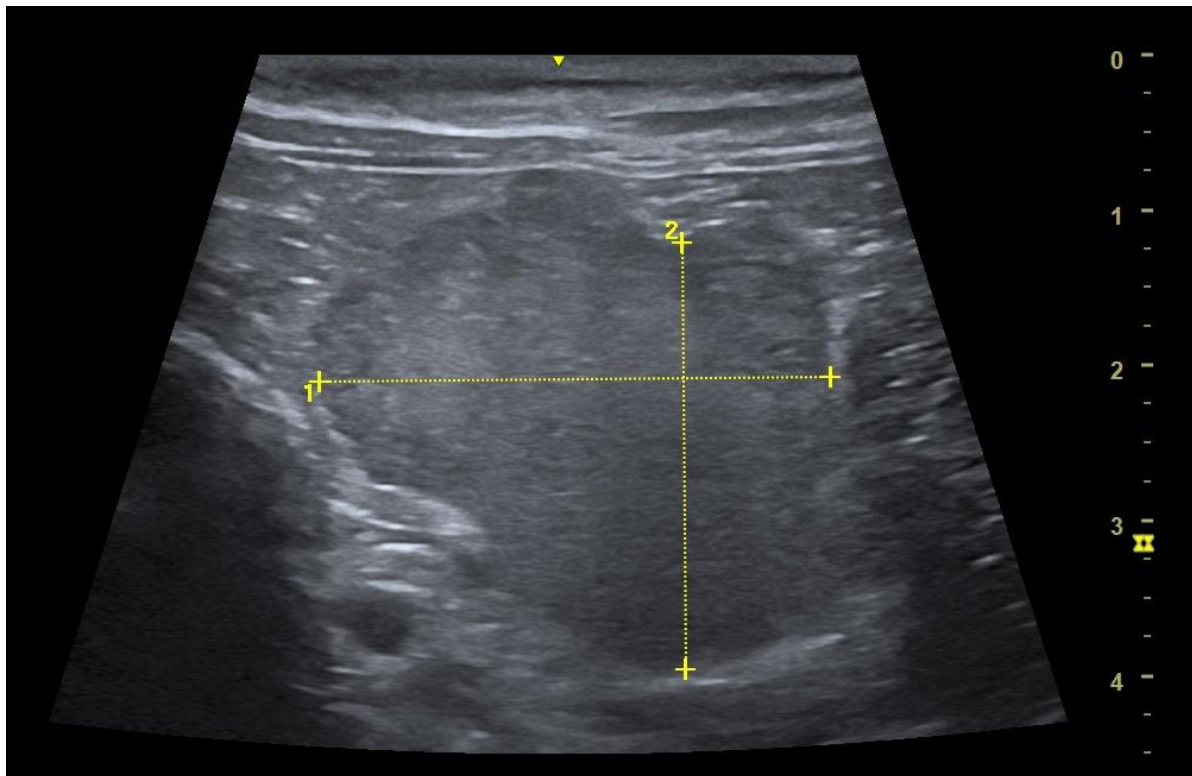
Abdominal ultrasonography showing an approximately 30 x 40 mm mass in the mid-cranial abdomen. Anatomic origin could not be determined.
